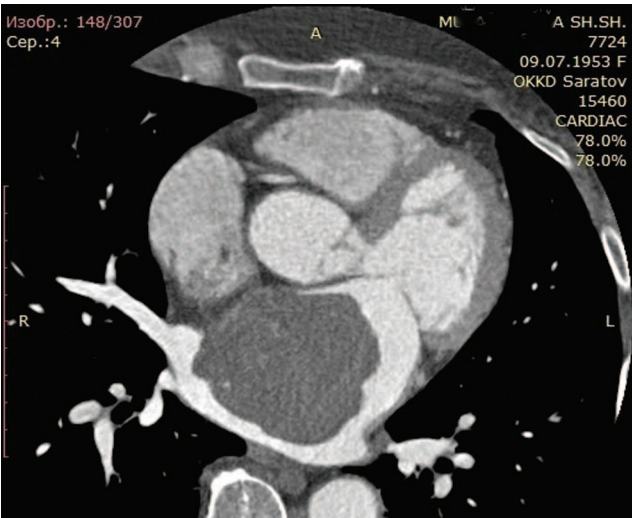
Cardiac computed tomography with contrast of patient M., 68 y.o.
